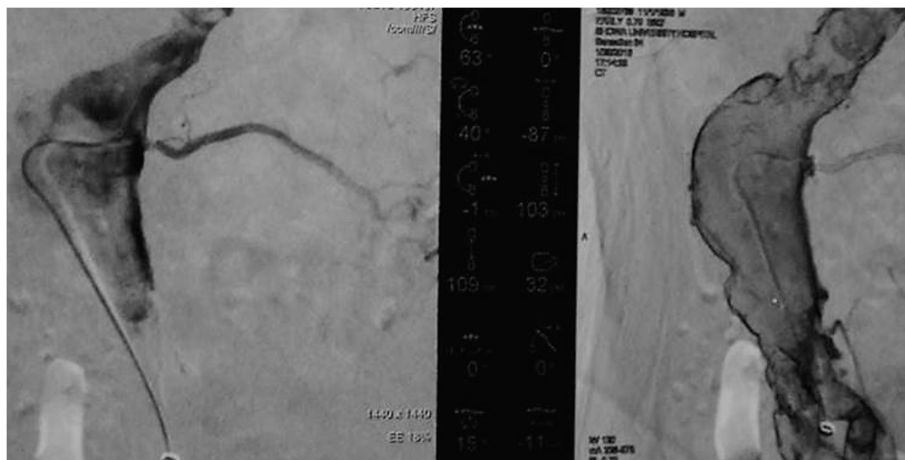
Fusion (right panel) and selective angiogram (left panel). Just before the procedure, preoperative computed tomography (CT) data was imported into Singo X-Workplace of Artic Zeego and volume rendering figure was constructed. Also 3D-CT data was obtained from Artuc Zeego (Syngo DynaCT). Then, preoperative CT data was matched with Syngo DynaCT. Consequently volume rendering figure could be visualized on fluoroscopy (Fusion image). Adequate direction of fluoroscopy to identify the origin of aortic side branch was adjusted by fusion image (right panel). Then aortic side branch was selected by angiogram (left panel).
